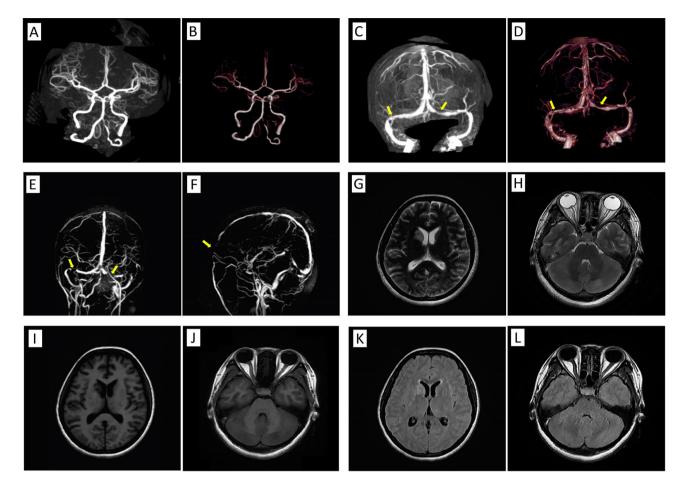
Imaging results of the patient on October 11. (A, B) Cranial CT angiography (CTA) and three-dimensional reconstruction; (C, D) Cranial CT venography and three-dimensional reconstruction reveal cerebral venous sinus thrombosis (arrows shown); (E, F) Brain magnetic resonance venous (MRV) imaging. The left transverse sinus is partially unclear. The left sigmoid sinus was slightly smaller than the opposite side, and display clearly. The junction between the right transverse sinus and the sigmoid sinus was not clearly displayed, and the filling defects in the superior sagittal sinus increased compared to before. (G-J) MRI T1 and T2 weighted images of the head; (K, L) FLAIR (brain magnetic resonance imaging fluid attenuation reversal recovery sequence). Multiple abnormal signal shadows with a slightly lower T1-weighted image (T1WI) signal, a slightly higher T2WI signal, and a higher DWI signal exist in the right basal ganglia, bilateral lateral ventricles, centrum semiovale, bilateral cerebellar hemispheres, and left basal ganglia, which hint inflammatory and infectious lesions
